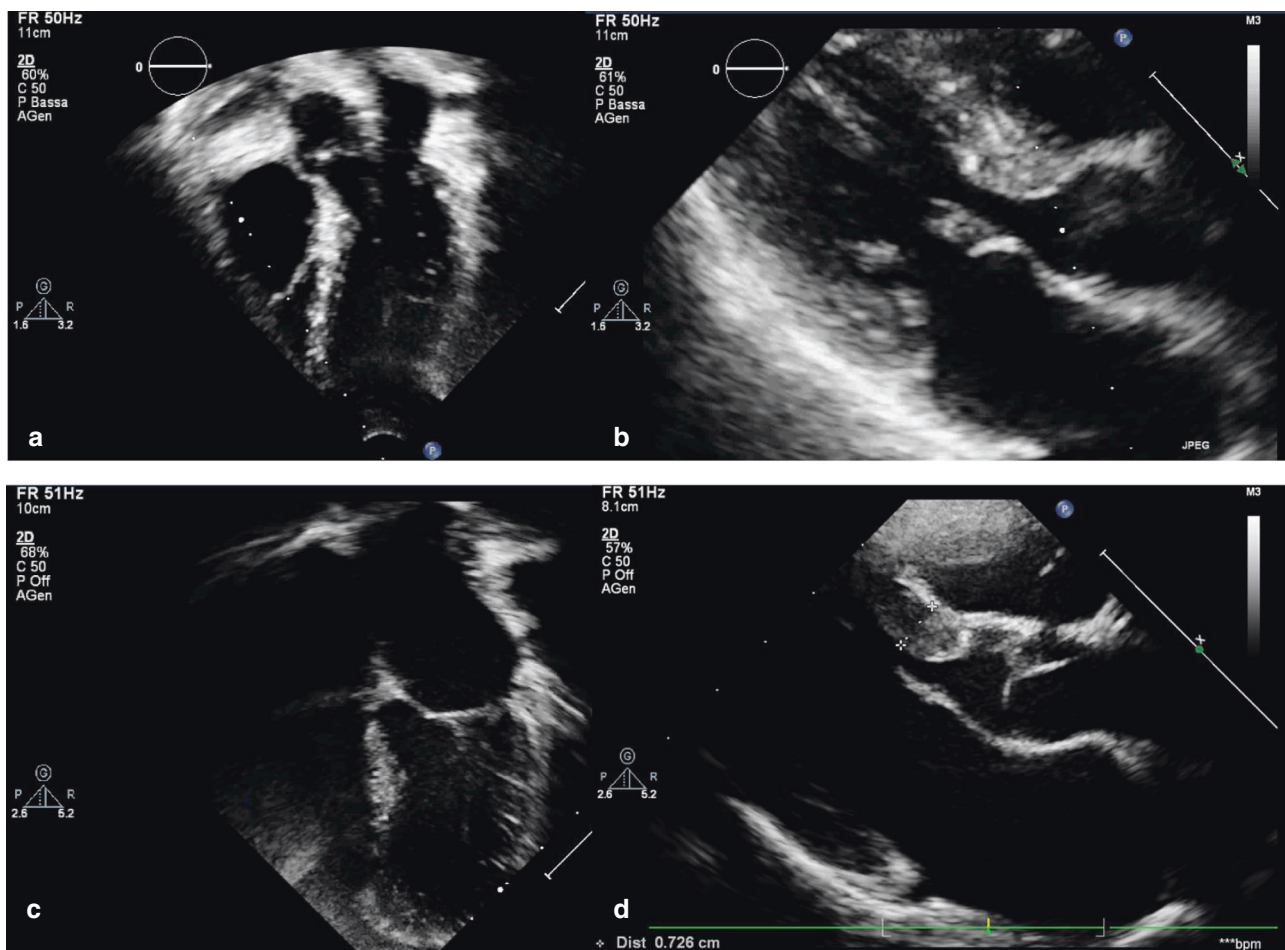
Sigmoid-shaped ventricular septum in patients with Noonan syndrome. The figure shows two examples of sigmoid-shaped ventricular septum morphology with isolated and localized thickening of its basal/mid septal segments, in echocardiographic apical 4-chamber (a, c) and parasternal long-axis (b, d) views in two Noonan syndrome patients (*PTPN11* in top frames, and *KRAS* in bottom frames). In both patients, a sigmoid septum and a ventricular septal bulge are shown to occur without hypertrophy of the rest of the ventricular septum.
